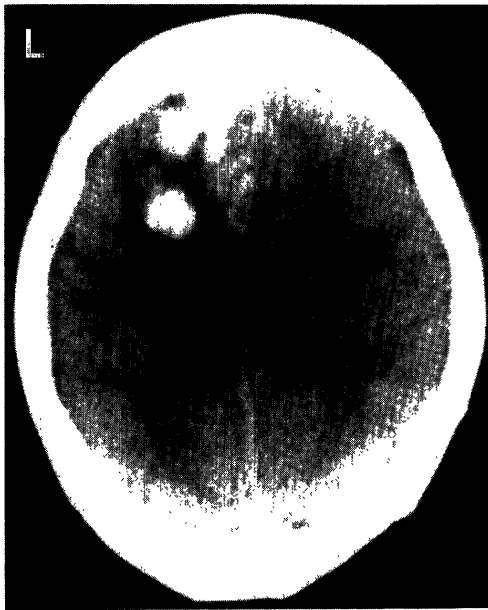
Computed tomography scan on admission showing a large hypodense area and other patchy hyperdense areas in the left frontal lobe with severe mass effect.
